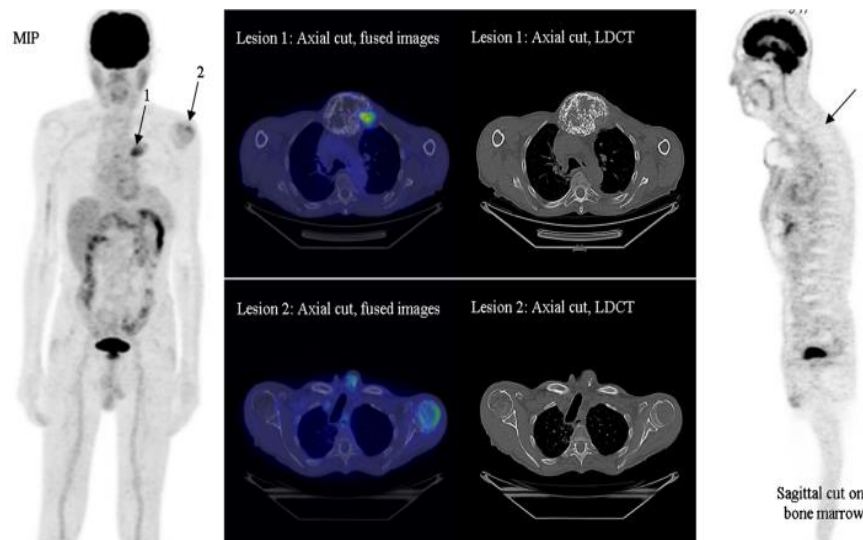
18F-FDG-PET/CT of a 77-year-old patient with a 100% concordance of interpretation between reviewers using IMPeTUs: BM 2 (bone marrow affection grade 2), 2 extra-spinal hypermetabolic lesions, PM (para-medullary lesion), L2 (2 lytic lesions) (19).
